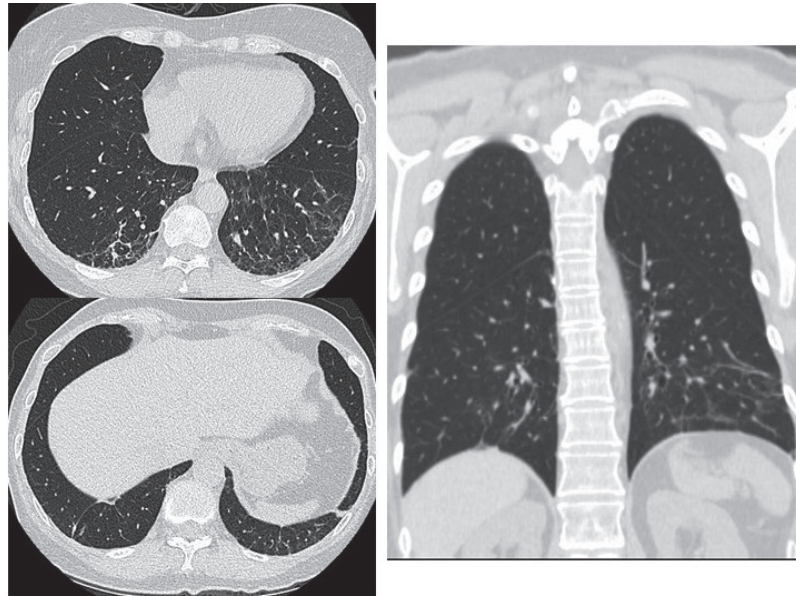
Follow-up HRCT 4 months later revealed significant resolution of the previous lung lesions.
